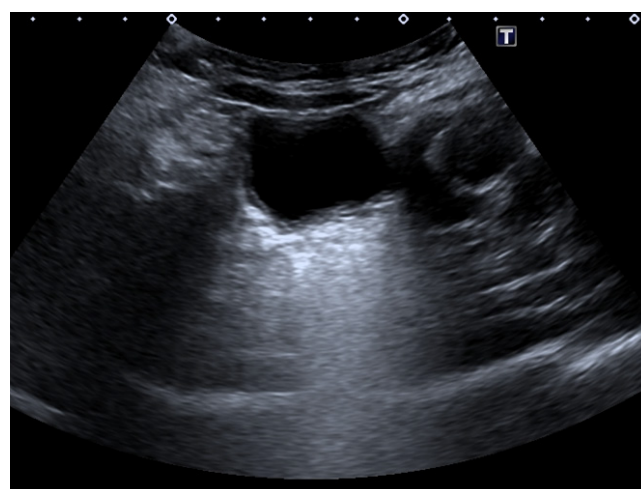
Ultrasonography 3
